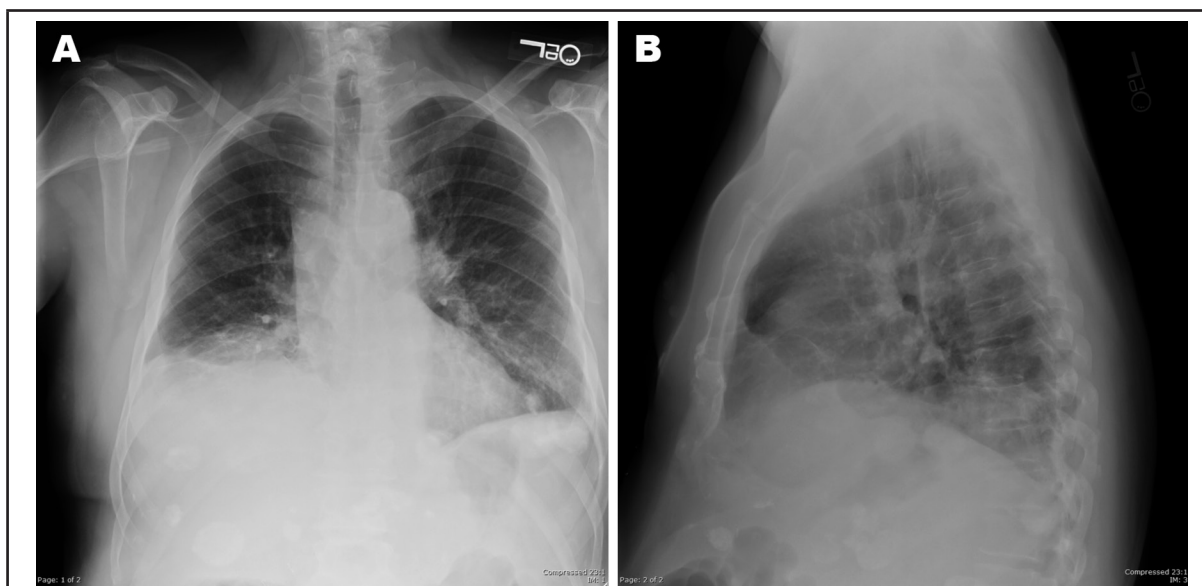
Plain anteroposterior (A) and lateral (B) radiographs of the chest taken postoperatively demonstrate marked improvement of right hemidiaphragm elevation.
